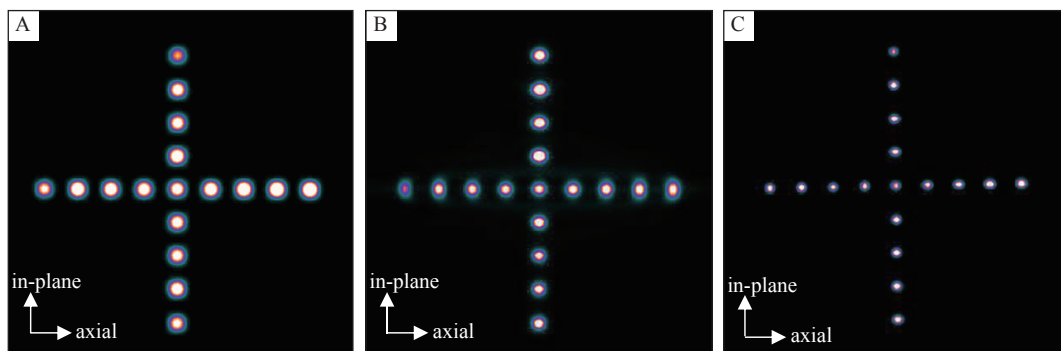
Images of point sources aligned in a cross shape. A: conventional Co-SPECT; B: quantitative Co-SPECT; C: PET.
